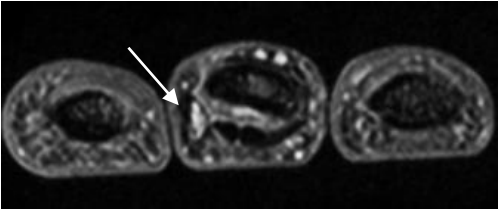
A. Preoperative gross appearance of the right middle finger. B. The high-intensity area as detected by magnetic resonance imaging showed neuroma of the digital nerve (arrow). C. Hypo-echoic areas in ultrasonography images showing neuroma of the radial digital nerve (asterisk).
